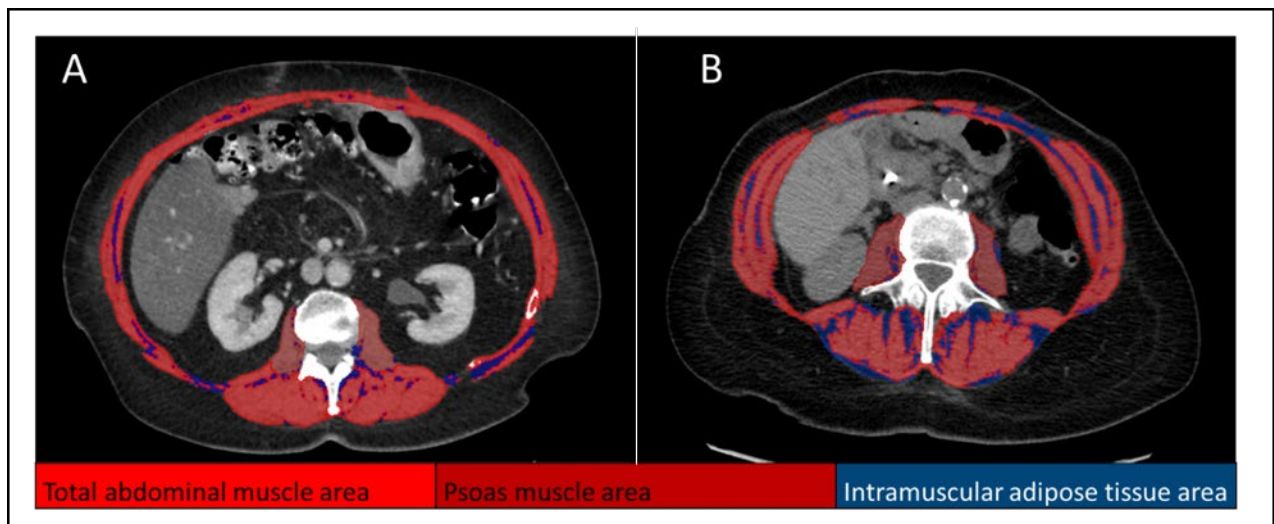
L3-L4 Computed Tomography scan.
